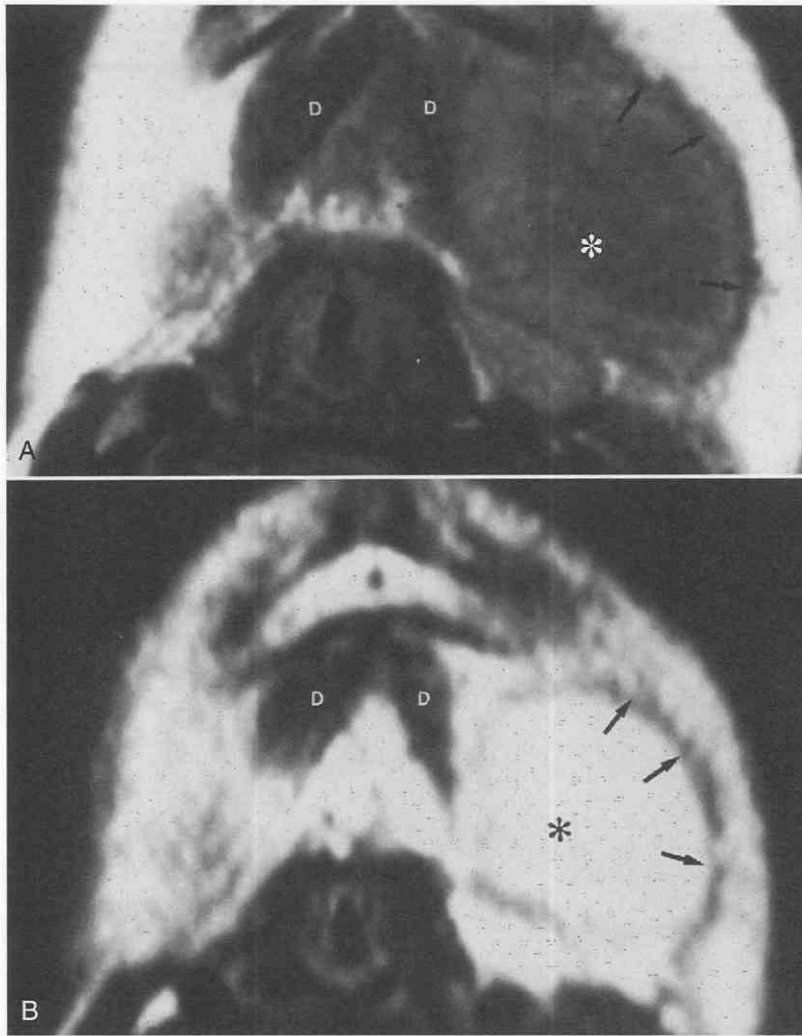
Abscess. *A*, Axial T1-weighted MR image demonstrates a mass (*asterisk*) in the right submandibular triangle that is hypointense to the anterior bellies of the digastric muscles. *B*, Corresponding axial T2-weighted MR image demonstrates hyperintense signal within the mass (*asterisk*). Note that inflammatory changes in the fat lateral to the abscess (*arrows*) are not as easily appreciated as on CT scans. (From Holliday RA, Prendergast NC: Imaging inflammatory processes of the oral cavity and suprahyoid neck. *Oral Max Surg Clin North Am* 4:215, 1992.)
